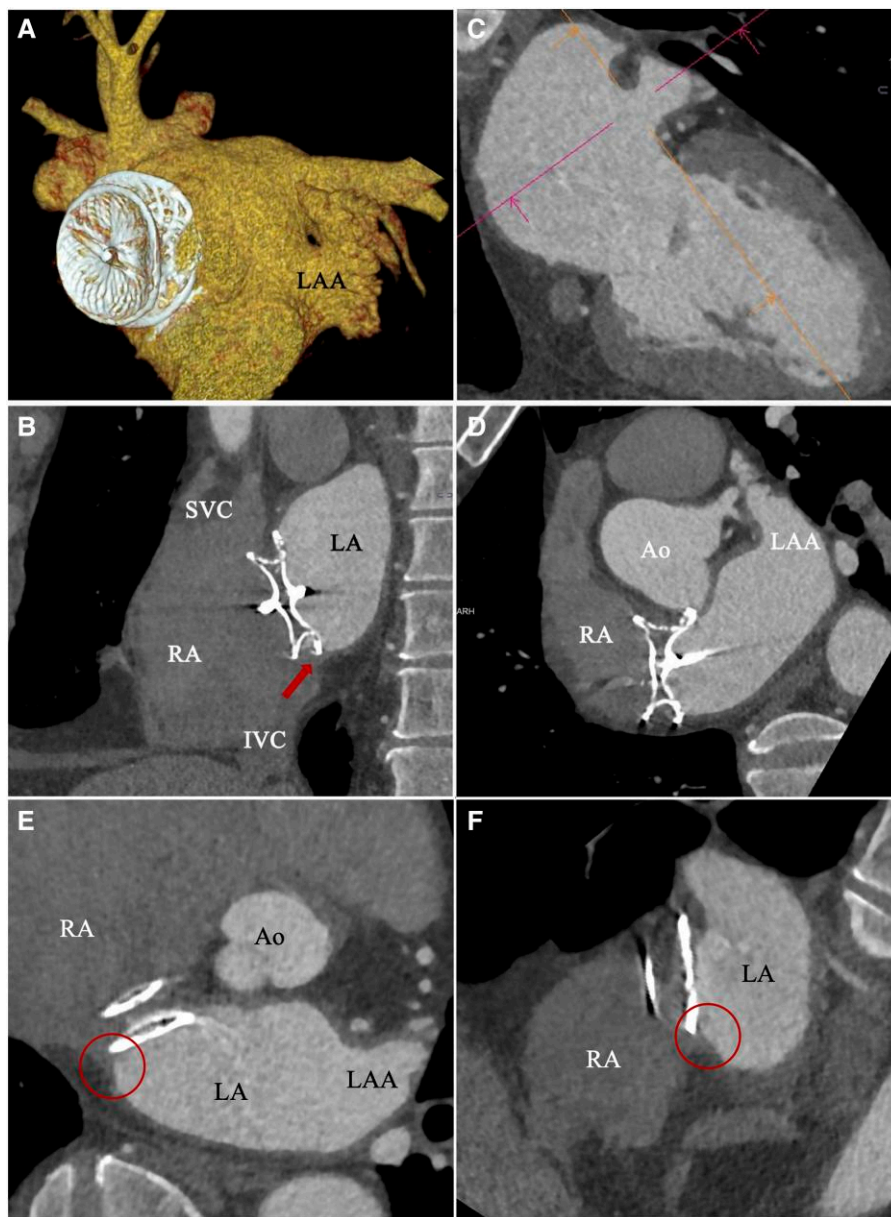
Preprocedural cardiac computed tomography. (A) 3D cardiac computed tomography of the left atrium, the Amplatzer Septal Occluder device (34 mm), and the left atrial appendage. (B) A small native interatrial septum can be visualized inferior to the Amplatzer Septal Occluder (arrow). (C) Cardiac computed tomography view of the left atrial appendage in a view corresponding to right anterior oblique 30° and cranial 10°. (D) Relationship between left atrial appendage and septal occluder device. (E and F) Visualization of the native interatrial septum (circle) at the posterior and inferior edge of the Amplatzer Septal Occluder, which measured 7 × 9 mm from the device edge to the atrial wall. Ao, ascending aorta; LA, left atrium; LAA, left atrial appendage; RA, right atrium; SVC, superior vena cava; IVC, inferior vena cava.
